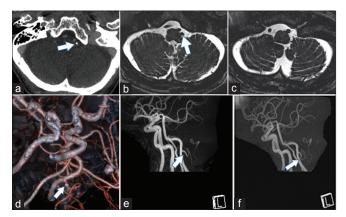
Preoperative images: plain CT (a) showing PICA aneurysm wall calcification (arrow); axial T2-WI (b and c) showing the left VA and PICA (arrow) running very close to the left HN rootlets (arrow); CTA (d) showing left PICA origin fusiform aneurysm (arrow); MRA showing the PICA (arrow) before (e) and after (f) transposition (arrow)
